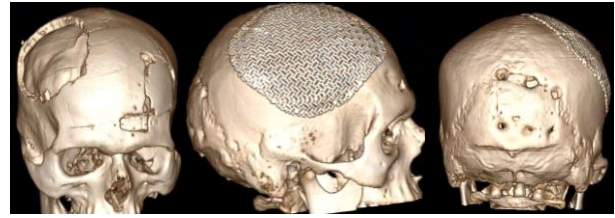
Preoperative and postoperative CT images demonstrating cranial reconstruction with a titanium mesh implant.
